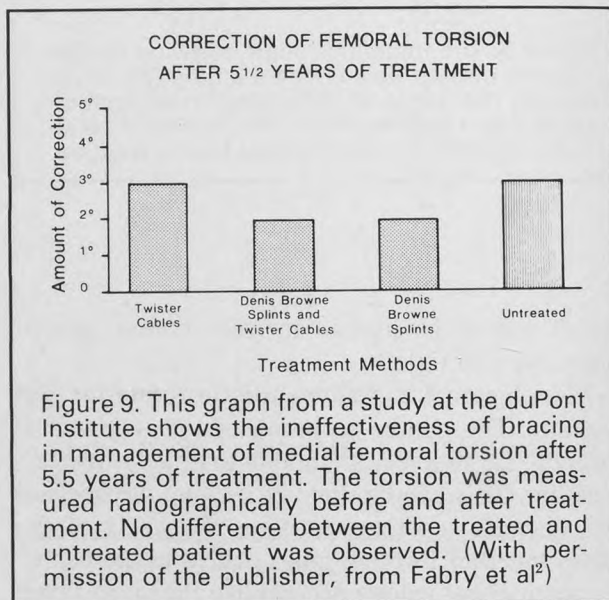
This graph from a study at the duPont Institute shows the ineffectiveness of bracing in management of medial femoral torsion after 5.5 years of treatment. The torsion was measured radiographically before and after treatment. No difference between the treated and untreated patient was observed. (With permission of the publisher, from Fabry et al<sup>2</sup>)
